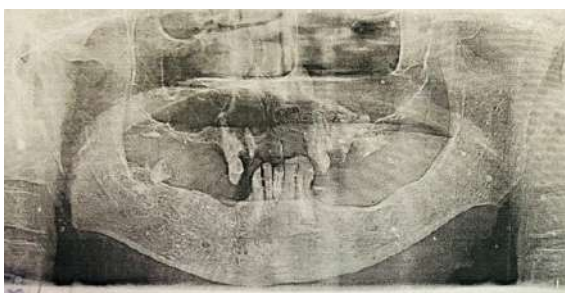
Radiographic Examination-OPG Showing well defined radiolucency involving apices from 12-14
